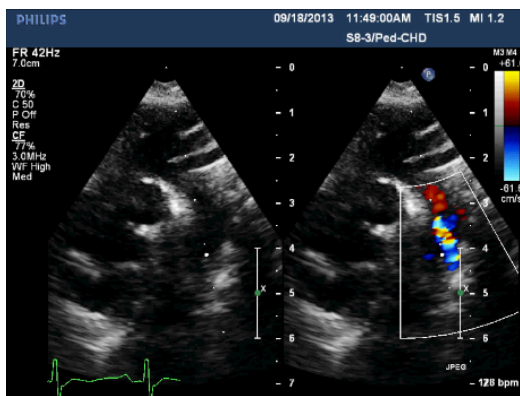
Colour Doppler image on flow reversal in proximal descending aorta.
